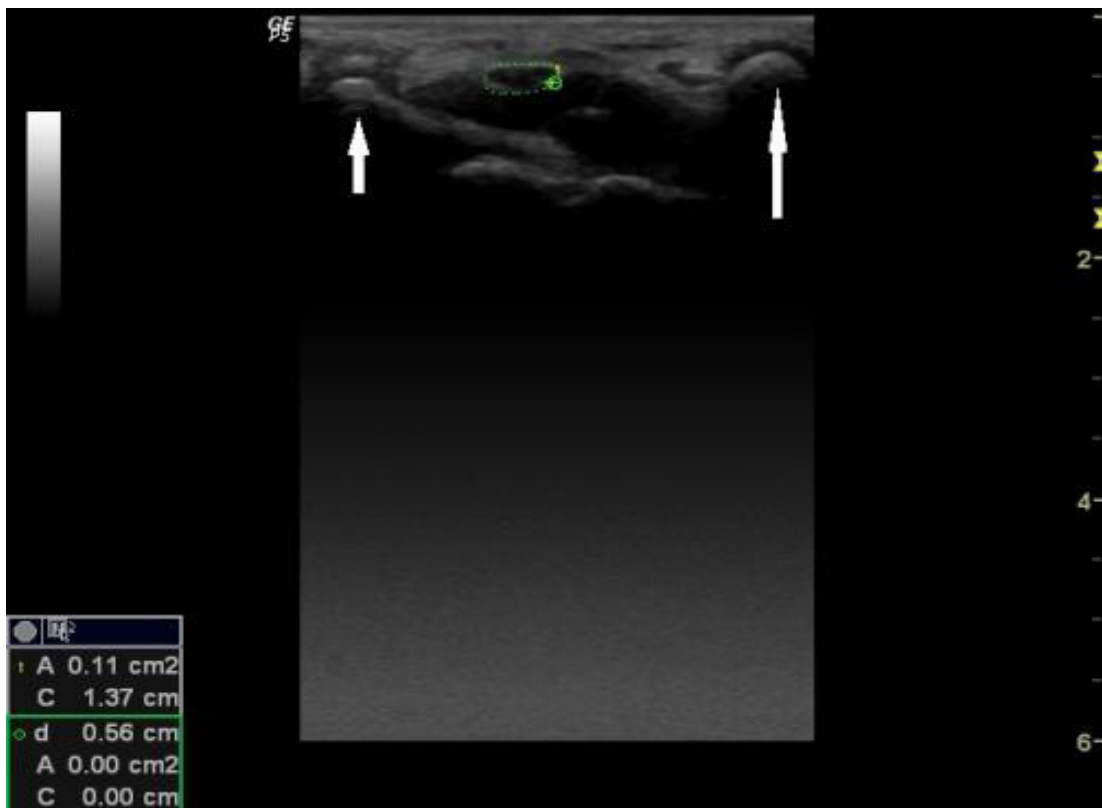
Ultrasonographic measurement of median nerve area.
